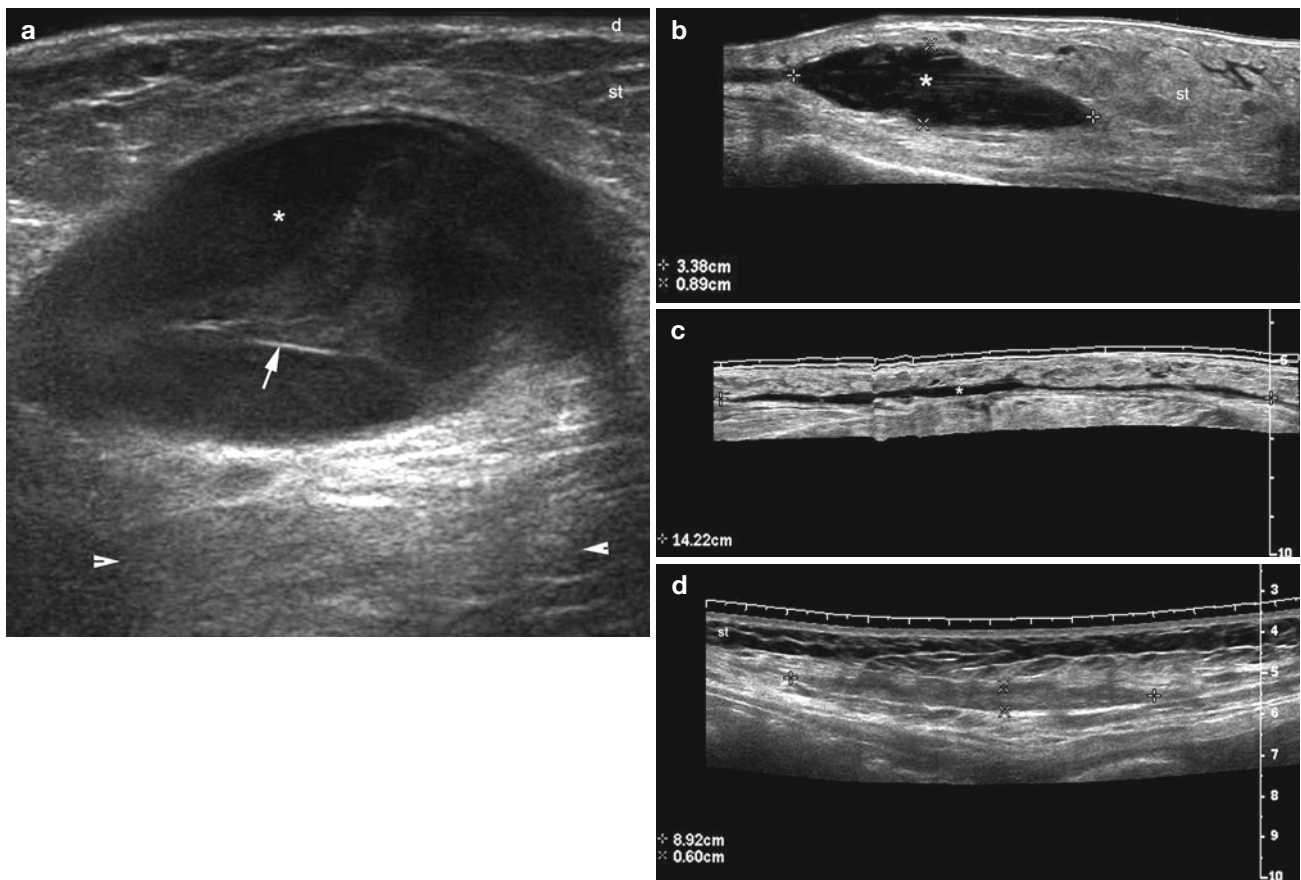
(a–d) Hematomas. Sonographic appearances of hematic fluid collections (* and between markers) going from large (a, b) to laminar deposits (c, d). Notice the posterior acoustic reinforcement (arrowheads)
